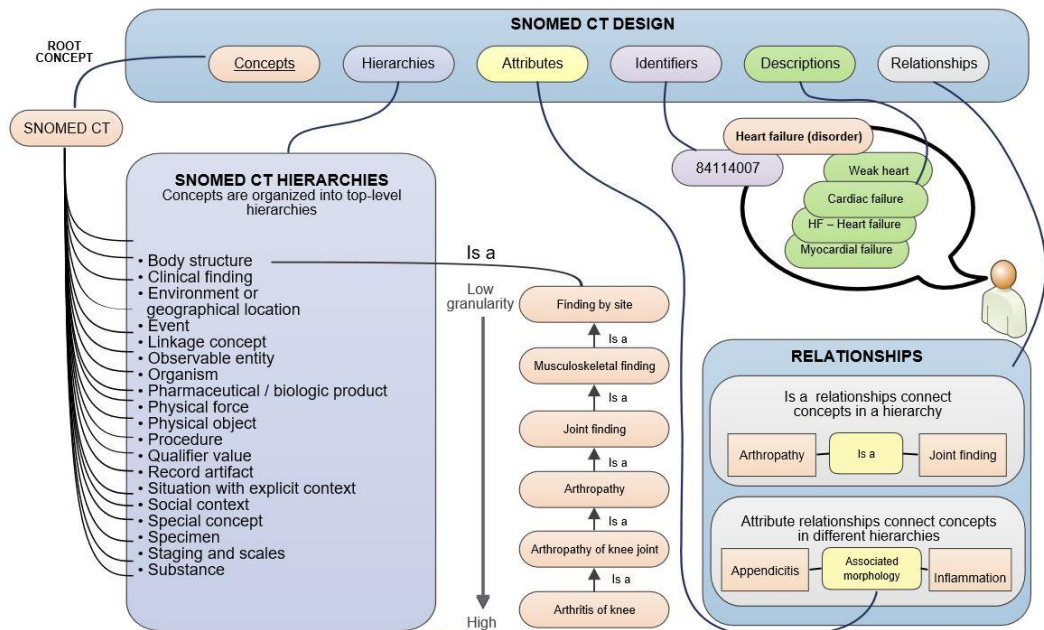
SNOMED CT hierarchy design
